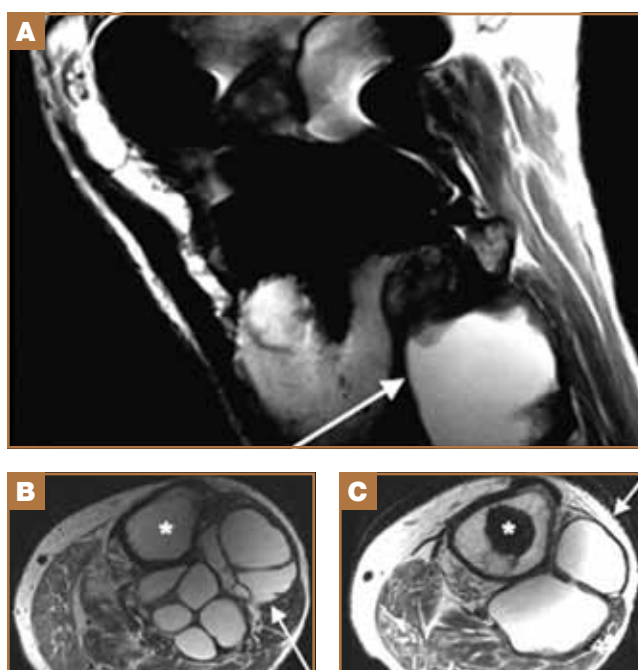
T2-weighted sagittal (A) and axial (B, C) MRI sequences of the left knee further defining the extent of the destruction. The arrows in the respective panels denote the discrete regions of osteolysis.
